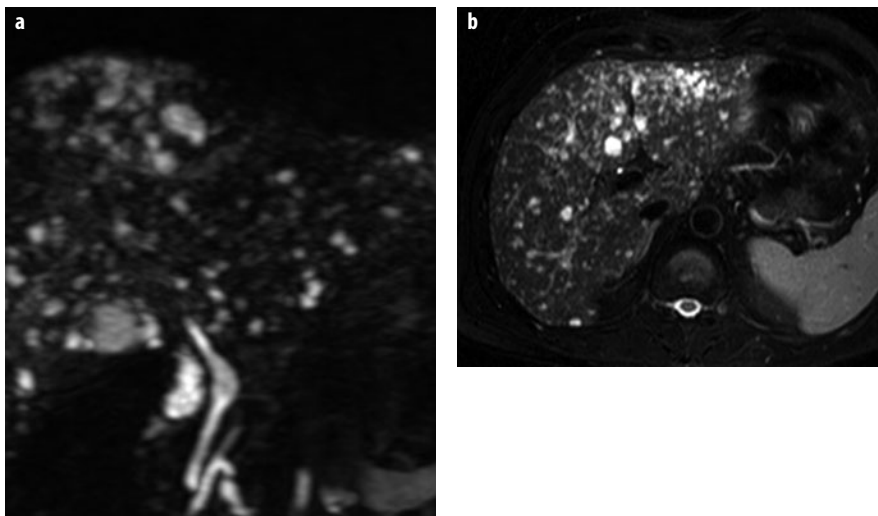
a, b. Biliary hamartomas (von Meyenburg complex). a, b Coronal and axial T2-weighted images show multiple small cystic lesions of different sizes and shapes (starry-sky appearance), typical for biliary hamartomas
